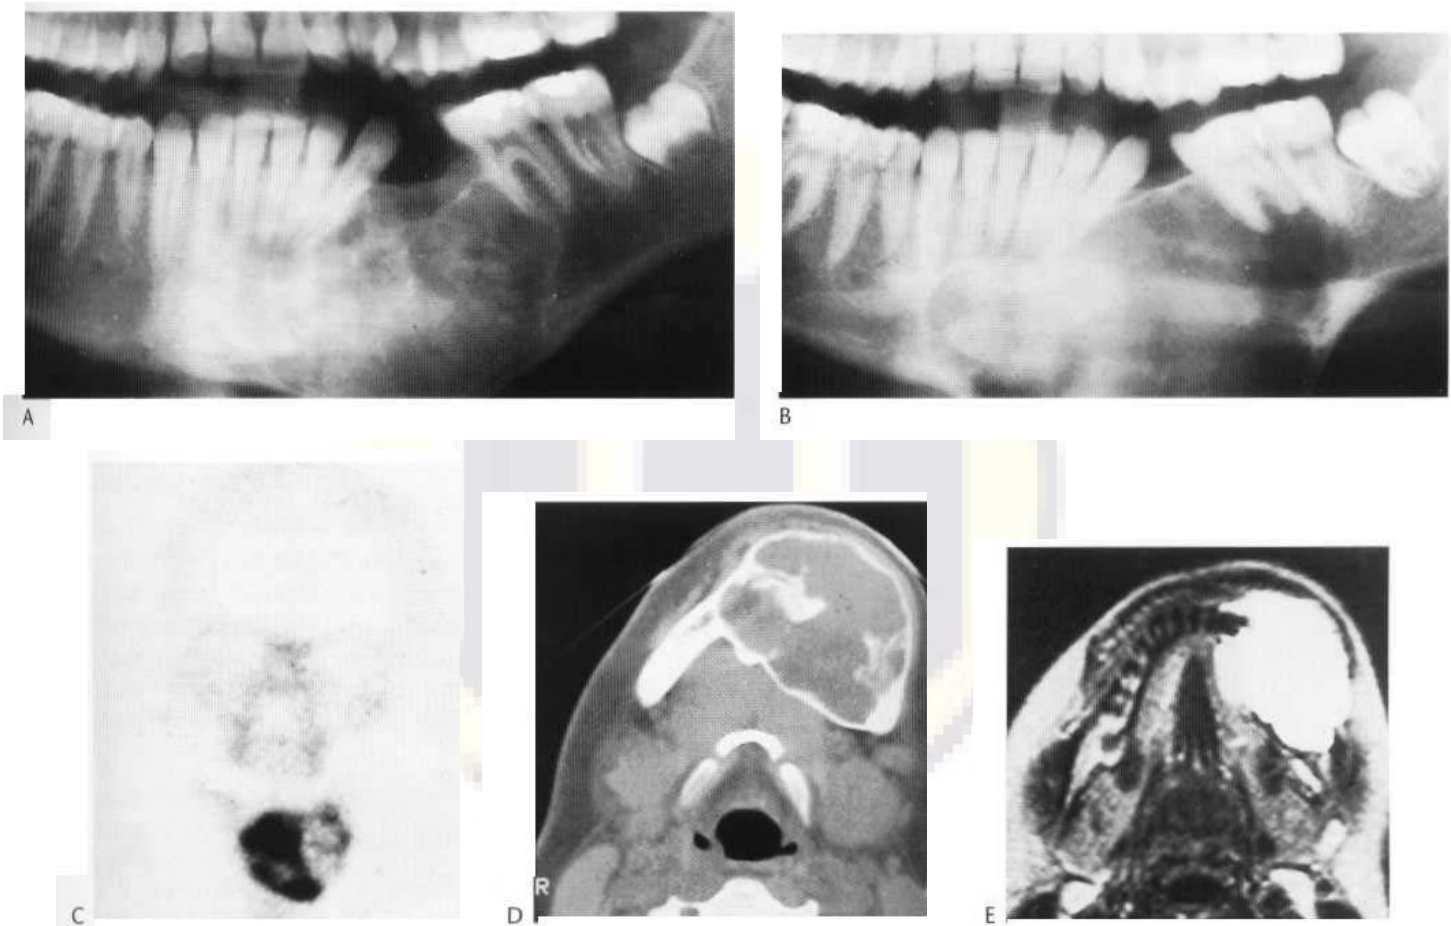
Fibrous dysplasia and resulting degeneration into aneurysmal bone cyst. (A) The initial radiograph shows an expansile, well-demarcated lesion displacing teeth; there is a mixed pattern of lysis and sclerosis. These changes are typical of fibrous dysplasia. Subsequently expansion took place (B) and the lesion became more cystic. (C) The bone scan at this time shows a mixed pattern with a central cold area. (D) The CT scan shows the expanded mandible and the now essentially cystic nature of the lesion. (E) MRI confirms the change in the nature of the lesion from a solid to a fluid-filled tumour.
